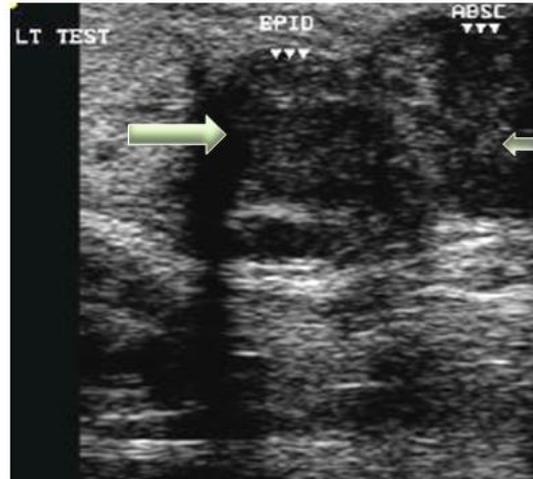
a: Diffuse involvement of both testis and epididymis with heterogeneous hypoechoic echotexture (High Frequency Ultrasound Image)
